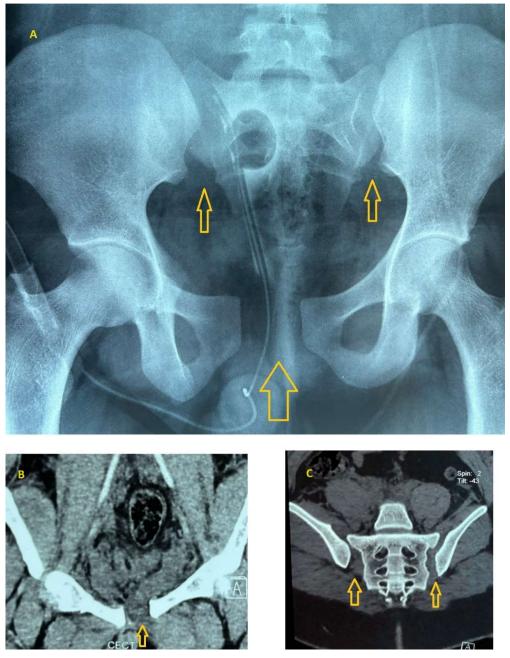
(A,B,C). Xray/CT showing pubic diastasis and SI joints subluxation
